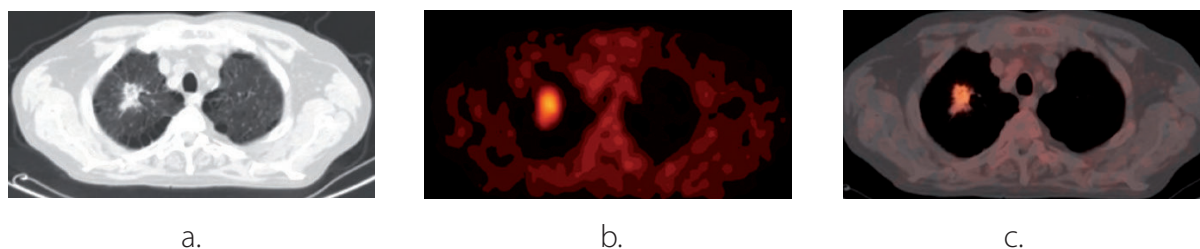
SPN characterisation:  $^{18}\text{F}$ -FDG uptake in a suspicious nodule. a CT of a 59-year-old man showing a 23-mm spiculated SPN in the right superior lobe. b  $^{18}\text{F}$ -FDG PET image with intense uptake in the nodule. c  $^{18}\text{F}$ -FDG PET/CT fused image (true positive)
